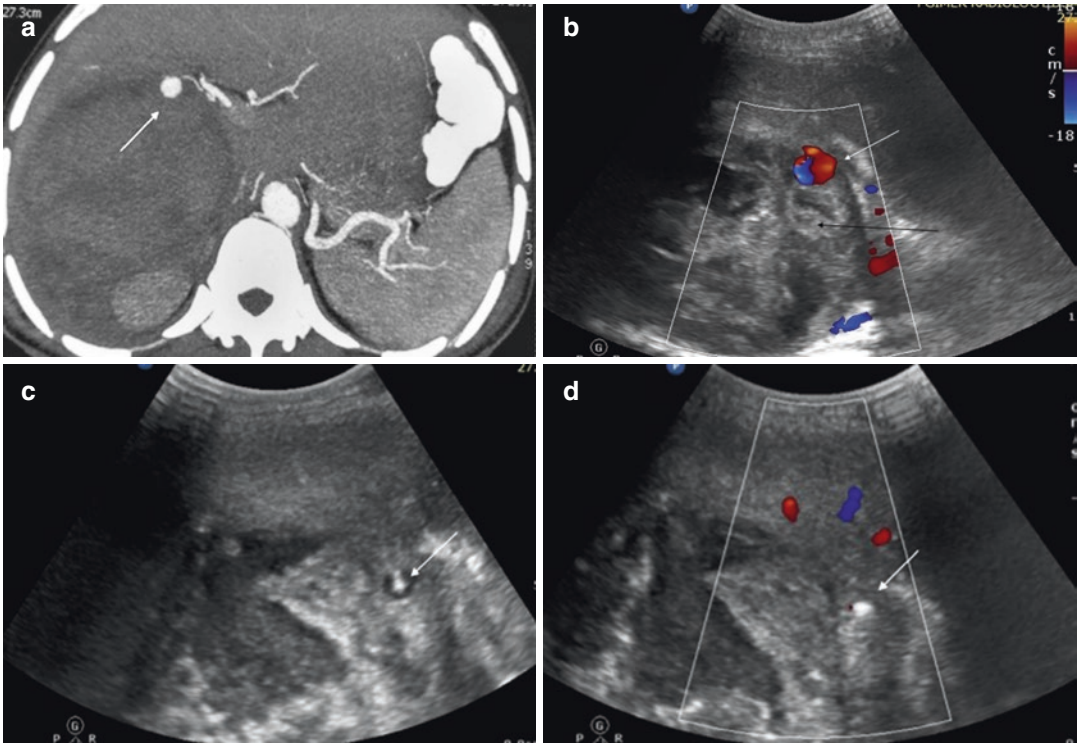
Blunt trauma abdomen with grade IV liver injury and hemobilia. (a) Axial CECT image showing pseudoaneurysm in relation to right hepatic artery (arrow) anterior to a large hematoma. (b) On colour doppler, pseudoaneurysm with yin-yang sign is seen. (c) Percutaneous
